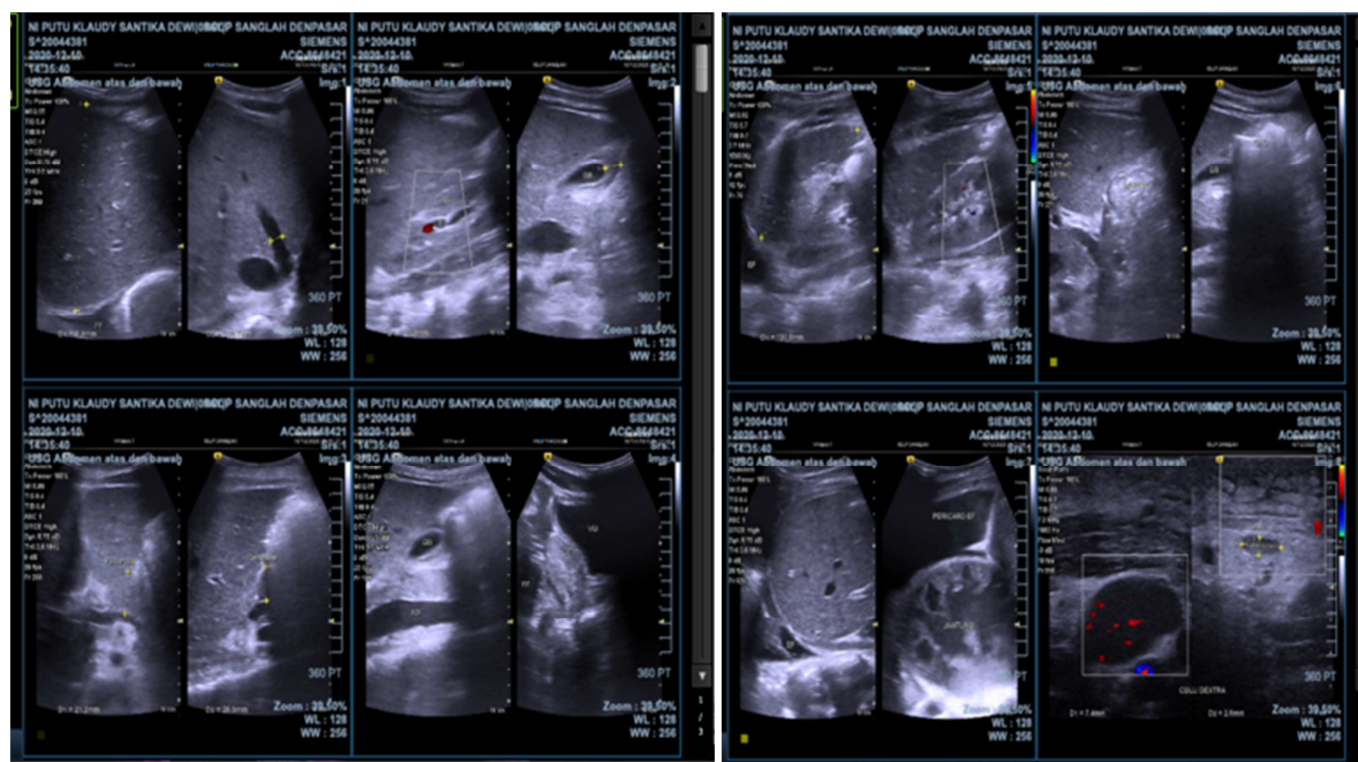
Ultrasonography abdomen.
